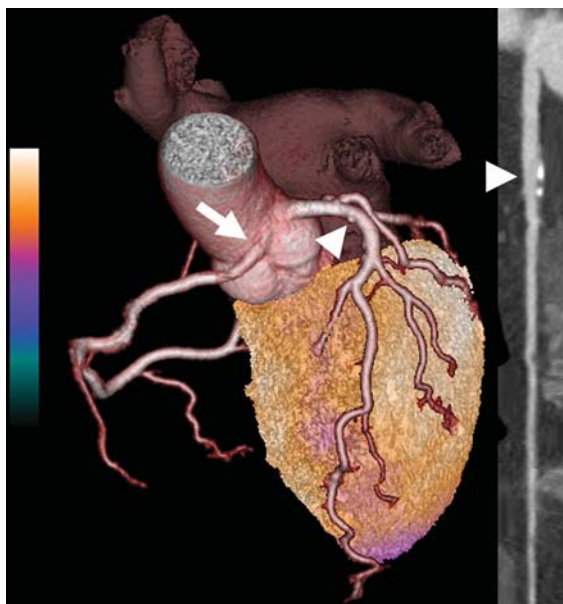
Fused stress ^{99m}Tc -tetrofosmin perfusion single-photon emission computed tomography/computed tomography coronary angiography image (radiation dose from computed tomography coronary angiography 1.3 mSv, from stress-single-photon emission computed tomography 2.2 mSv) reveals normal myocardial perfusion, but non-significant vessel wall irregularities in the proximal left anterior descending artery (arrows heads), as well as a coronary anomaly (arrow; origin of the right coronary artery from the left coronary sinus).
